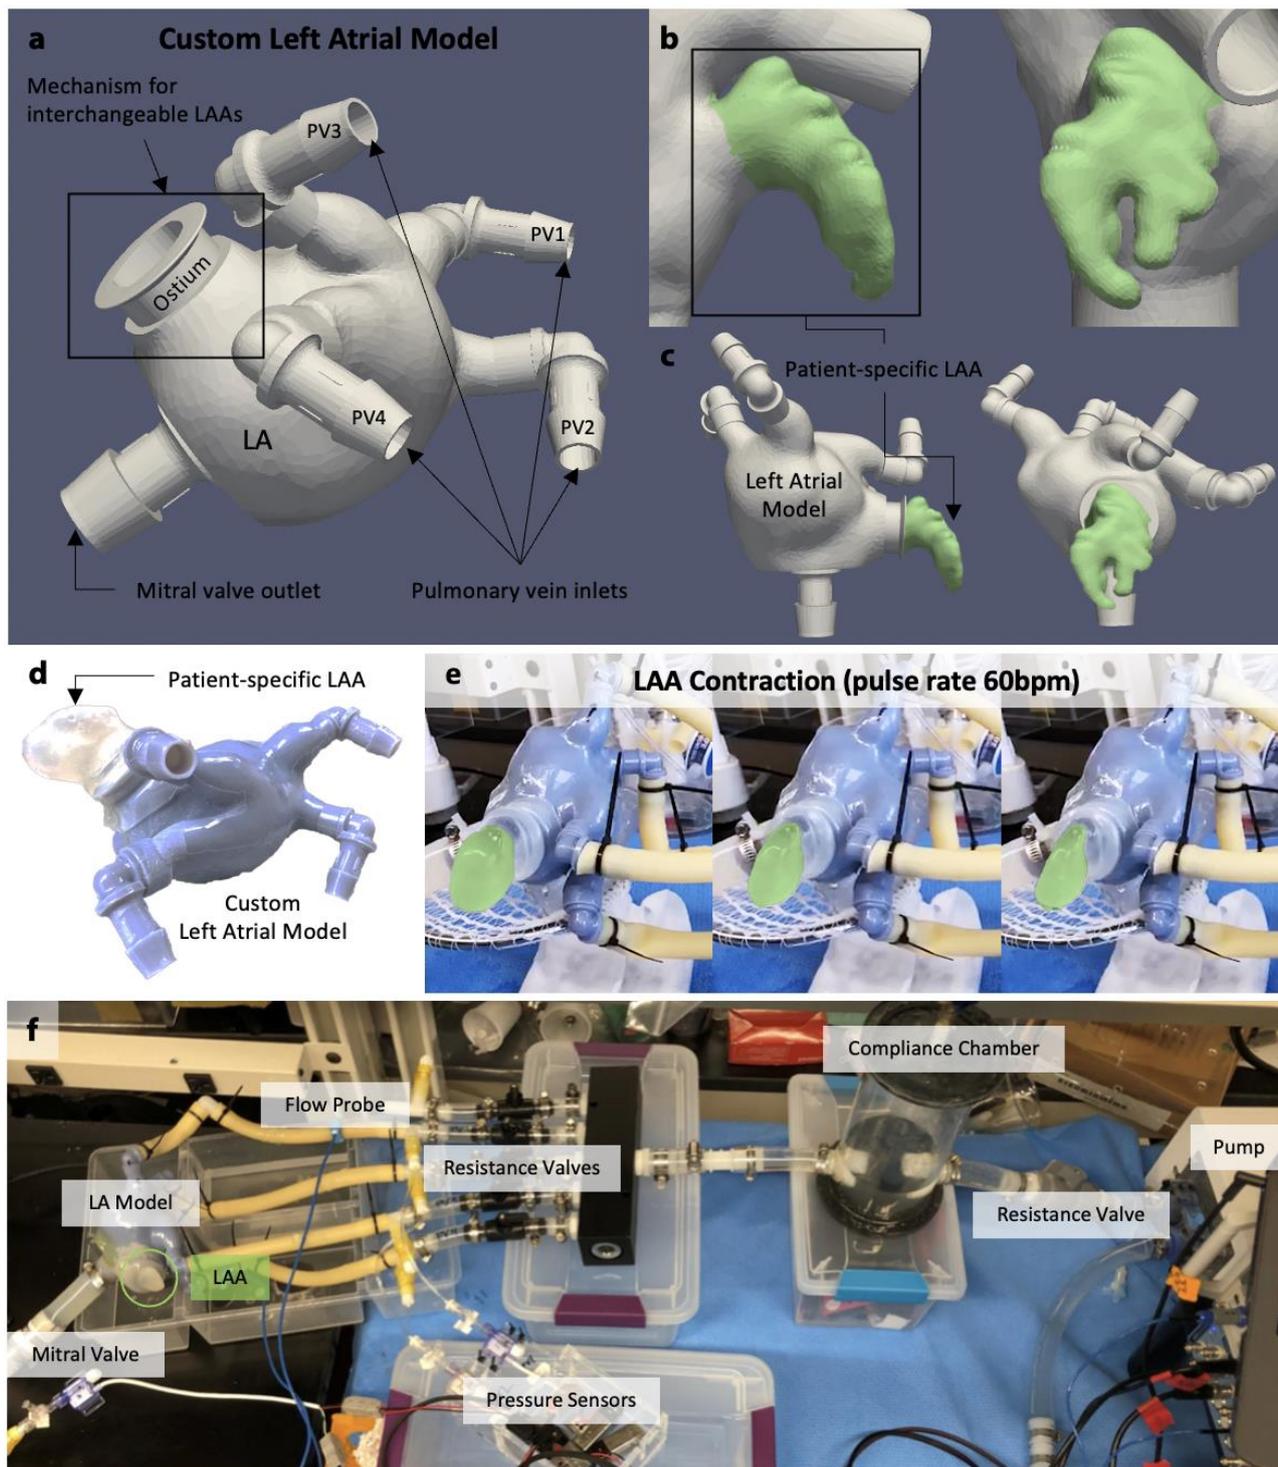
(a) Custom, patient-derived LA model with the mechanism for interchangeable LAAs. Barbed fittings at inlets and outlet for incorporation into circulatory flow loop. (b) Patient-specific LA and LAA segmented from CT imaging. (c) Patient-specific LAA from (b) shown on custom LA model from (a). (d) 3DP custom LA with patient-specific silicone LAA attached. (e) Contraction of LAA using a pulsatile pump (pulse rate 60bpm). (f) Benchtop circulatory flow loop with LA model, LAA (inside green circle), mitral valve, pulsatile pump, tunable resistance/compliance elements, pressure sensors, and flow probes.
